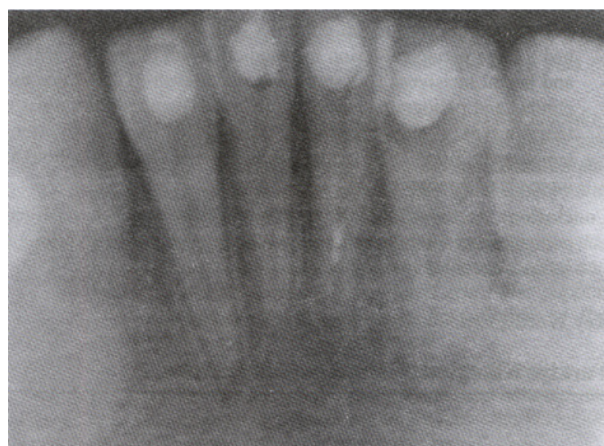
The radiographic evaluation of case at the end of 12 months.
